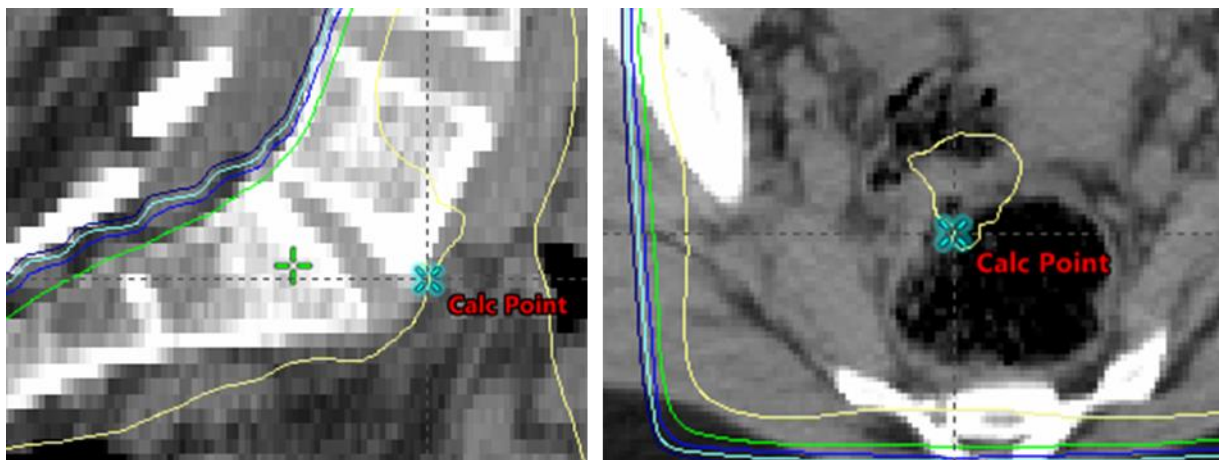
Examples of patient plans that were flagged for high and low density (left and right, respectively). The plan flagged for high density had a CT number of 548 at the 90th percentile, and the plan flagged for low density had a CT number of -375 at the 10th percentile.
